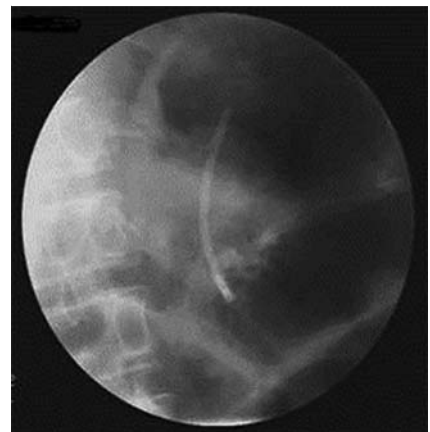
Radiographic image of the stent inserted in the main pancreatic duct.
